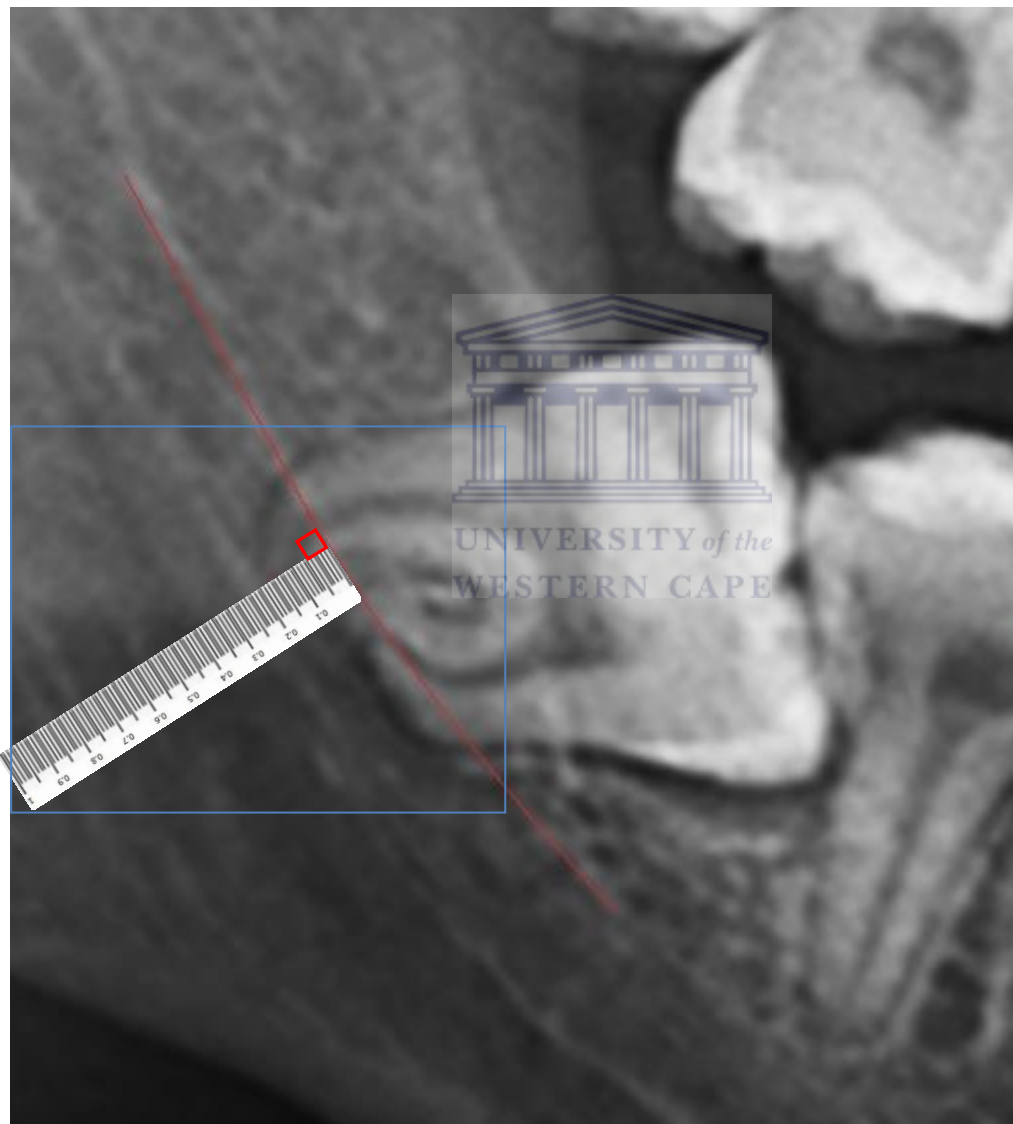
A cropped panoramic radiograph which is magnified at 500% in the Microsoft Word's spread sheet. This magnification is according to the magnification factor of the magnified standard one centimetre ruler used in this study. Manipulation of the image size, contrast and brightness level were made to assist in the image measurement.
